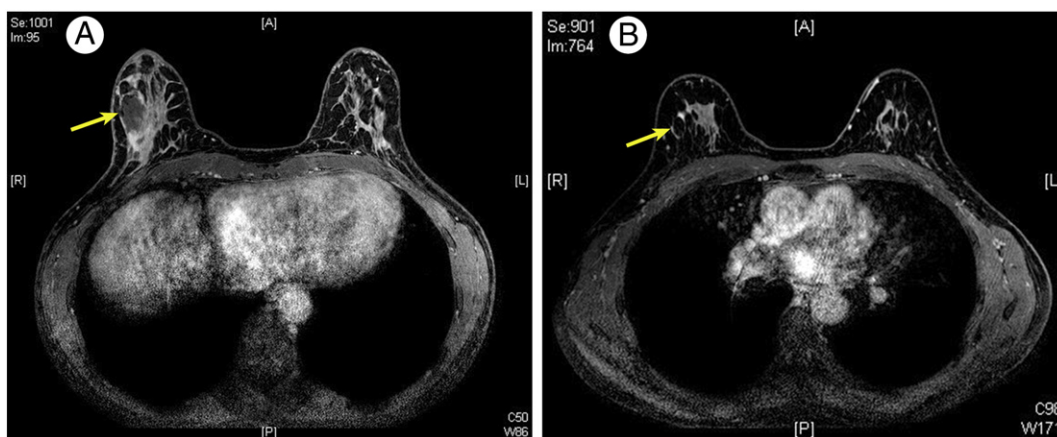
Magnetic resonance imaging of the right breast, enhanced T1 high-resolution isotropic volume excitation (eTHRIVE). A, Imaging demonstrates a 4.0×2.2 cm ovoid fluid collection in the lateral right (9:00) breast following excisional biopsy of the first lesion. B, An additional 0.5 cm ring-enhancing mass within the upper outer (11:00) right breast.
